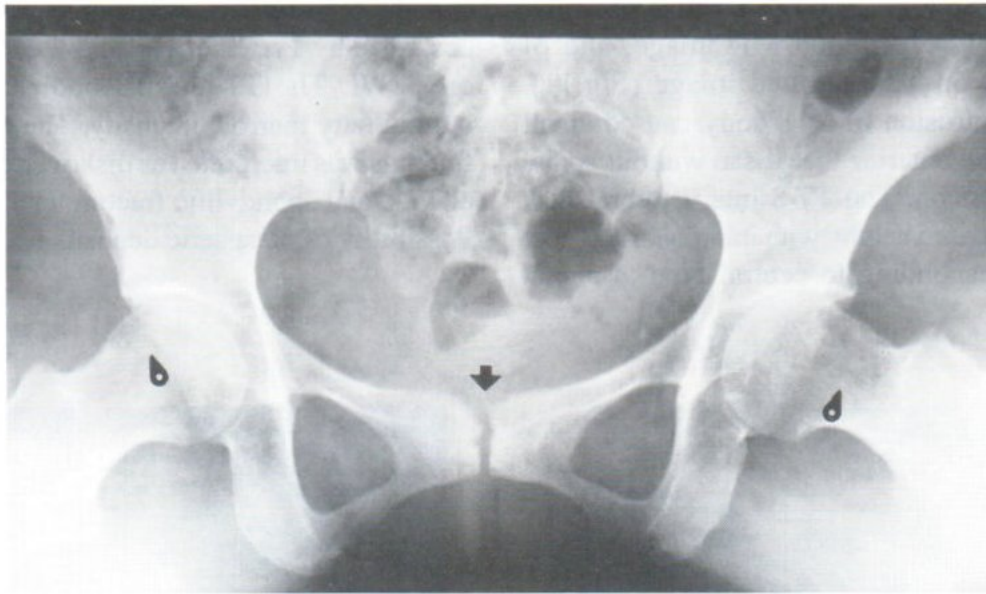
AP radiograph of both hips (frog leg view) demonstrates extrinsic erosion at femoral head-neck regions (round arrowheads). The pubic symphysis exhibits bone erosion and sclerosis of subchondral bone (arrow).
